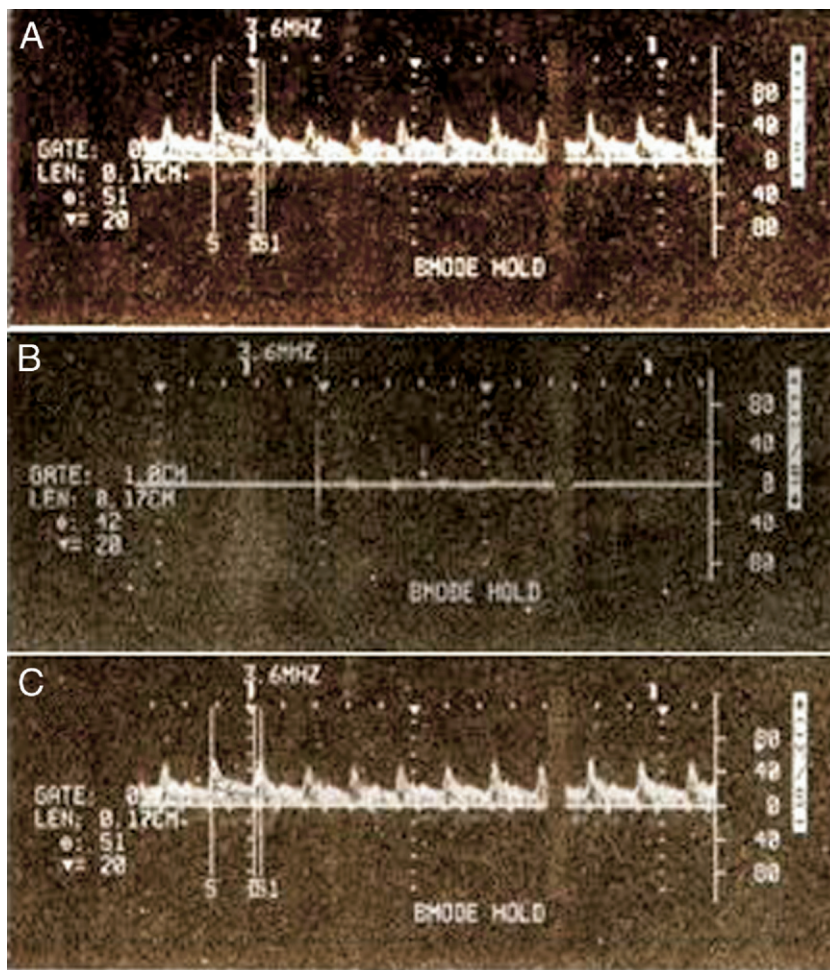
Blood Velocity Profile and 2-Dimensional Echo-Doppler Graft Examination
